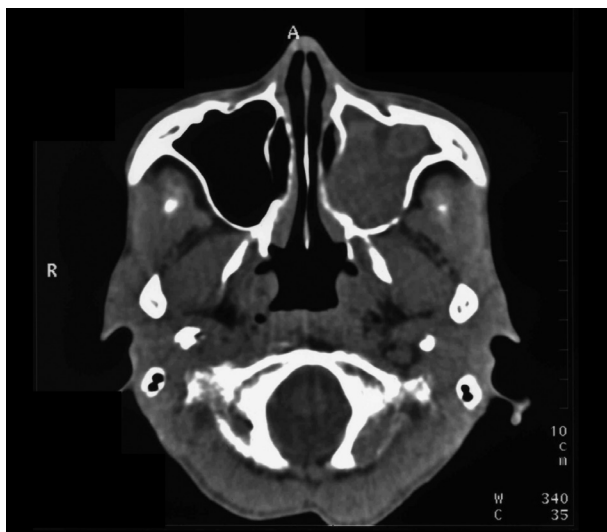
Plain CT of case 2 showing a well-defined expansile mass in the left maxillary sinus.
